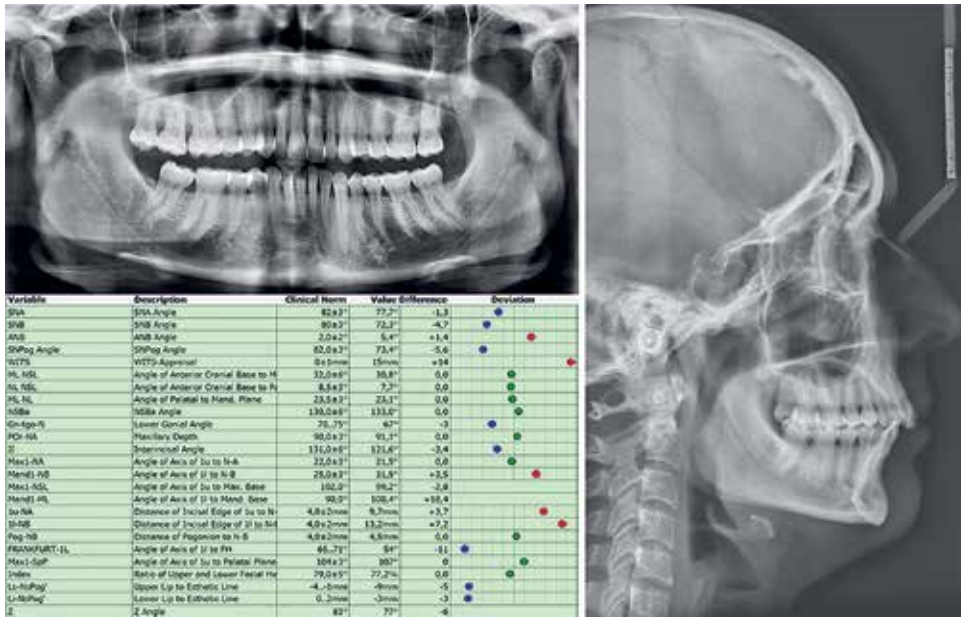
Panoramic and lateral cephalometric radiographs and cephalometric analysis.
